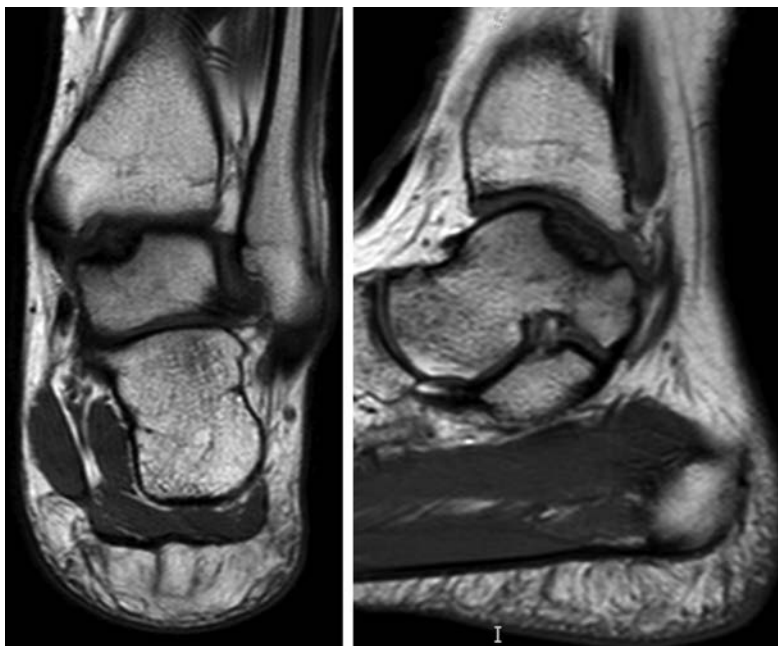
Sagittal and coronal T1-weighted MRI of the left ankle in a 14-year-old female soccer and field hockey player. She had a history of bilateral pes planus and frequent ankle sprains and was subsequently found to have osteochondral lesions over the superomedial talar dome in both ankles, as well as vitamin D deficiency.
